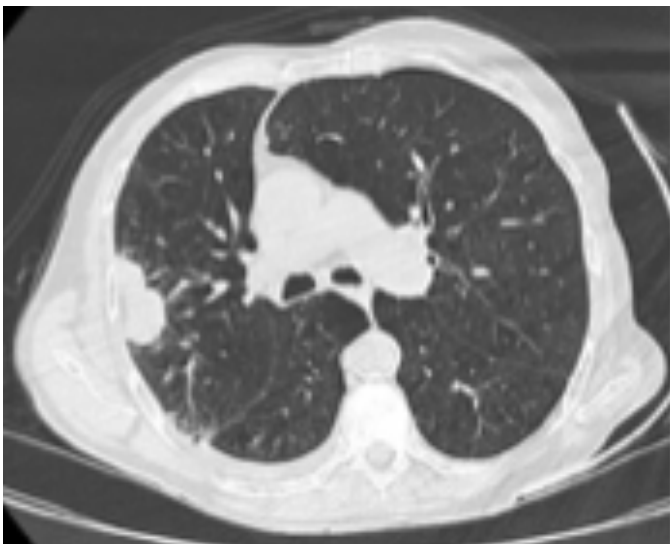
Thoracic CT at diagnosis, September 2024: right upper lobe mass measuring 43 x 54 mm, in contact with the lateral costal pleura.
